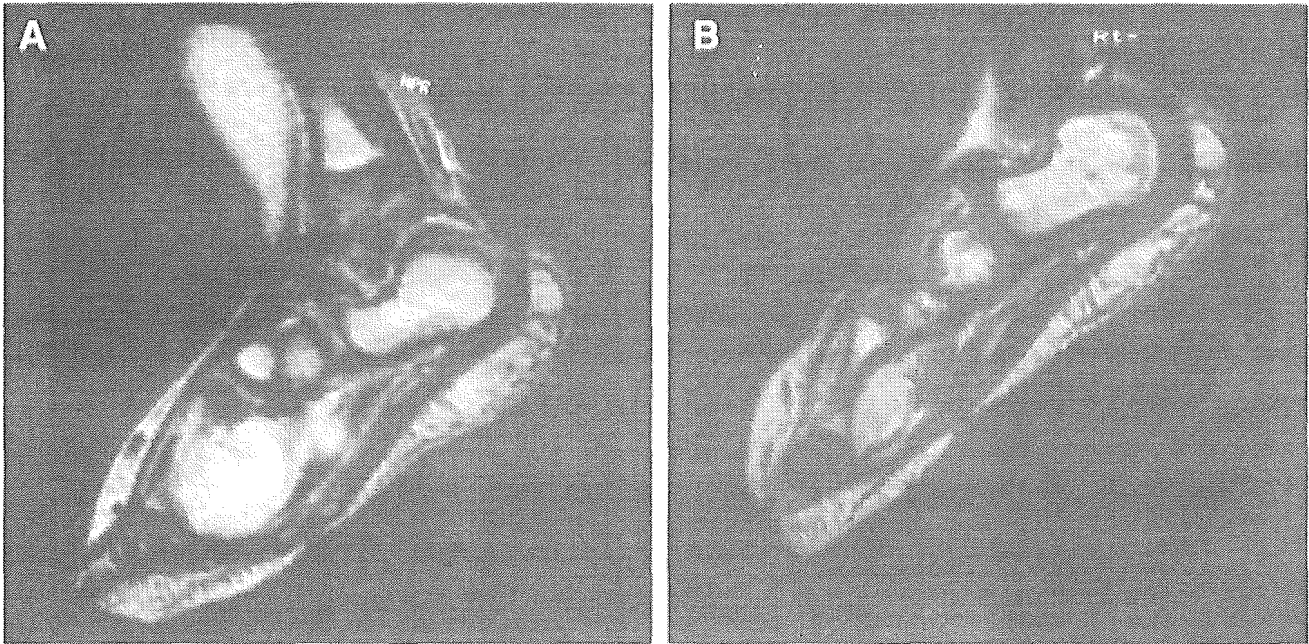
MRI findings of rhabdomyosarcoma (Case 1). A: Before preoperative chemotherapy, a sagittal T2-weighted image depicted the tumor as a high signal intensity localized in the plantar region of the foot, involving muscles and metatarsal bones. B: After preoperative chemotherapy, the tumor size was remarkably decreased.
